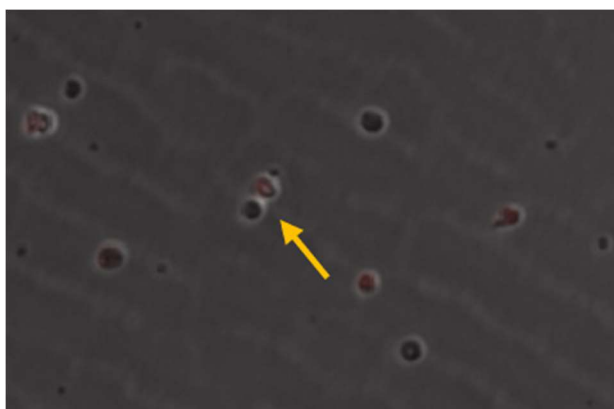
Representative image of a cell-cell interaction in a Nikon CT Biostation
